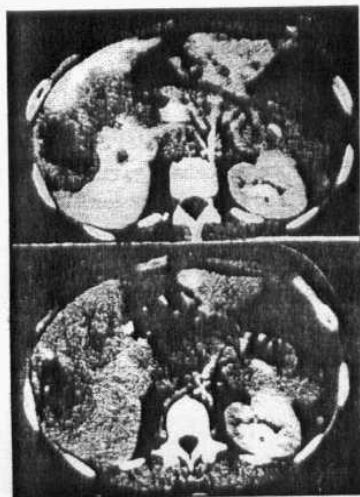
(a): CTAP detected a metastatic lesion not detected by DS-CT (b) of the same patient.
